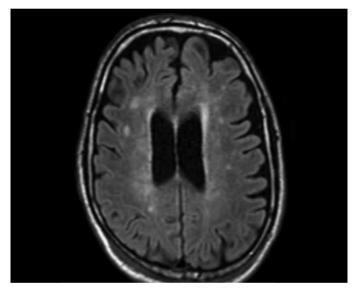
Cranial MRI; millimetric signal enhancements being concordant with chronic microangiopathic ischemic gliotic foci in white matter were determined in the level of the periventricular field, bilateral corona radiata and centrum semiovale in MRI
